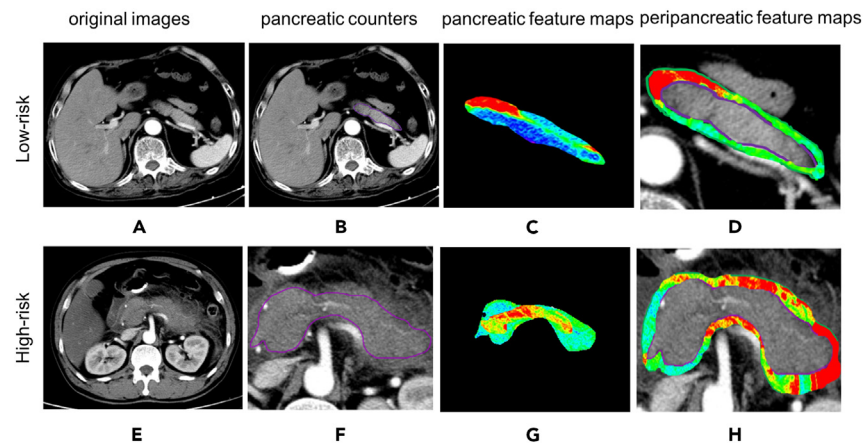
Pancreatic and peripancreatic radiomics features expression of Abdominal contrast-enhanced CT images for high and low-risk acute pancreatitis with AKI
